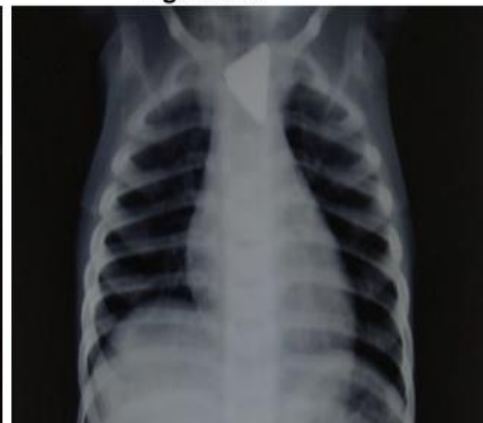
X-ray wise location of the foreignbody
